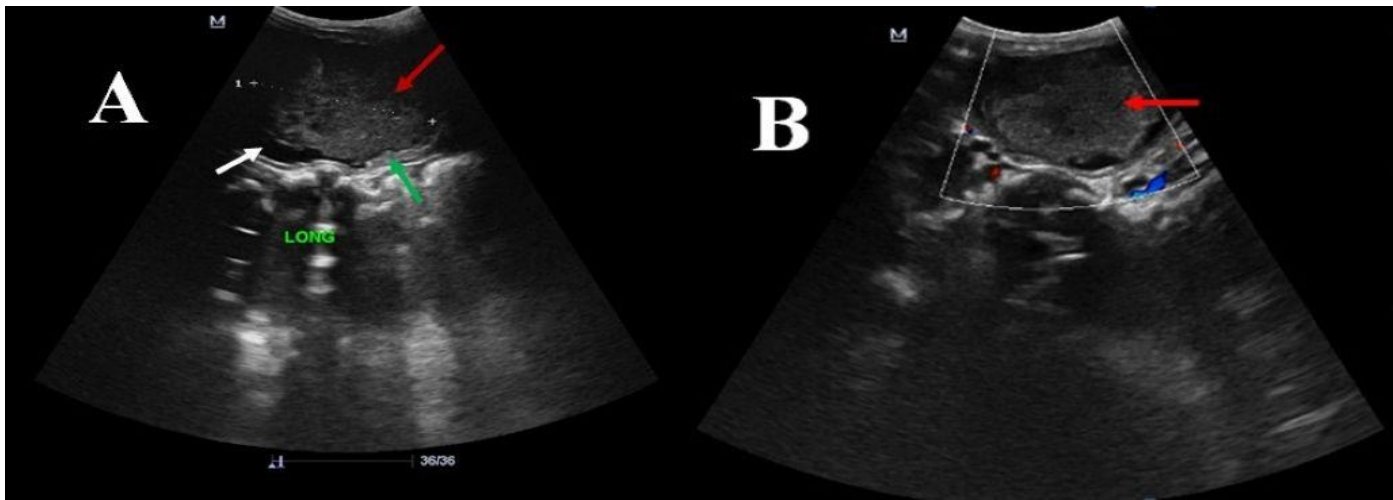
Pelvic ultrasound, longitudinal (A) and transverse (B) views, showing a huge, lobulated, minimally hyperechoic mass arising from the bladder base (red arrow) in keeping with a rhabdomyosarcoma. The bladder wall is thickened (green arrow). No significant vascularity on Doppler insonation (B).
